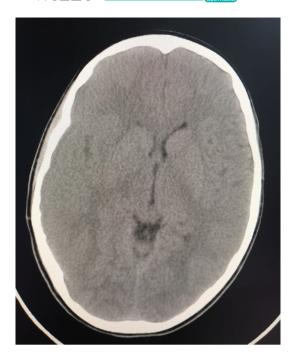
CT brain at presentation: mild diffuse brain edema of the right cerebral hemisphere
